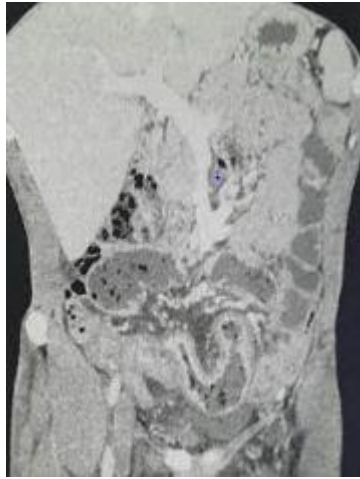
Abdominal computed tomography sagittal showing aspect of mesenteric panniculitis
